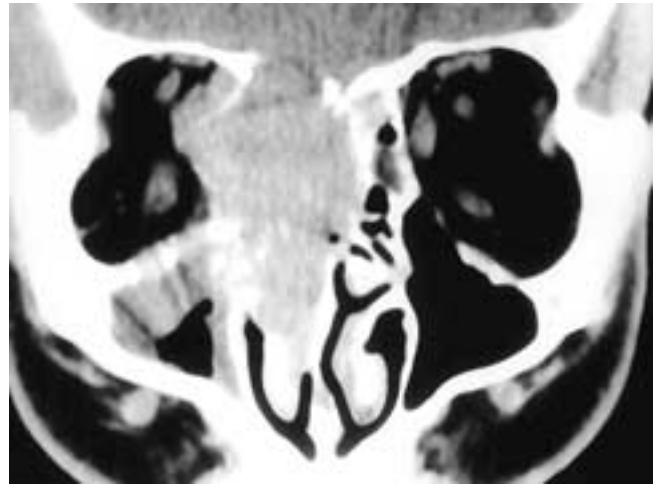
Coronal CT scan shows a bulky soft-tissue mass in the right ethmoid and nasal cavity. The tumor has invaded the right orbit and the floor of the anterior cranial fossa. There is also obstruction of the right antrum. This is a more aggressive appearance of a large cell lymphoma and, based on the imaging appearance, could be a carcinoma.
